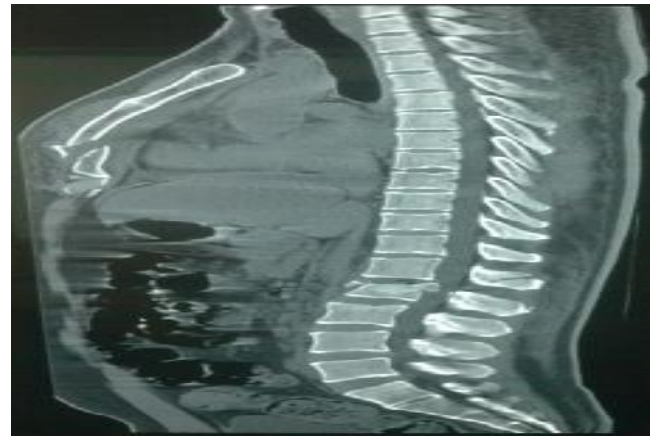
Sagittal CT image showing L1 burst fracture with sternum fracture
